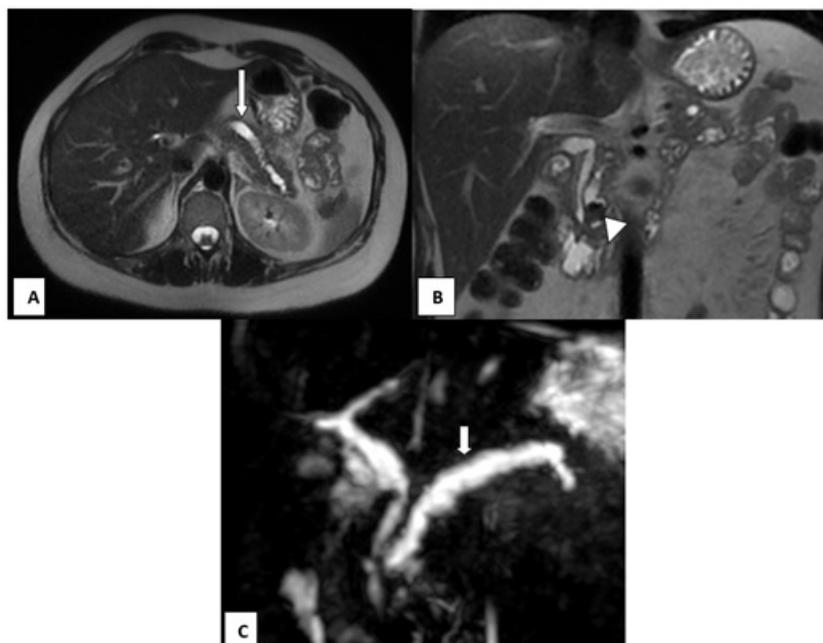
Pancreatic-MRI on T2 weighted sequence with axial (A) and coronal (B) sections and 3D MRCP (C) showing a pancreatic atrophy (Arrow) with dilatation of the Wirsung (Short arrow) upstream of a calculi in the cephalic portion (Arrowhead).
